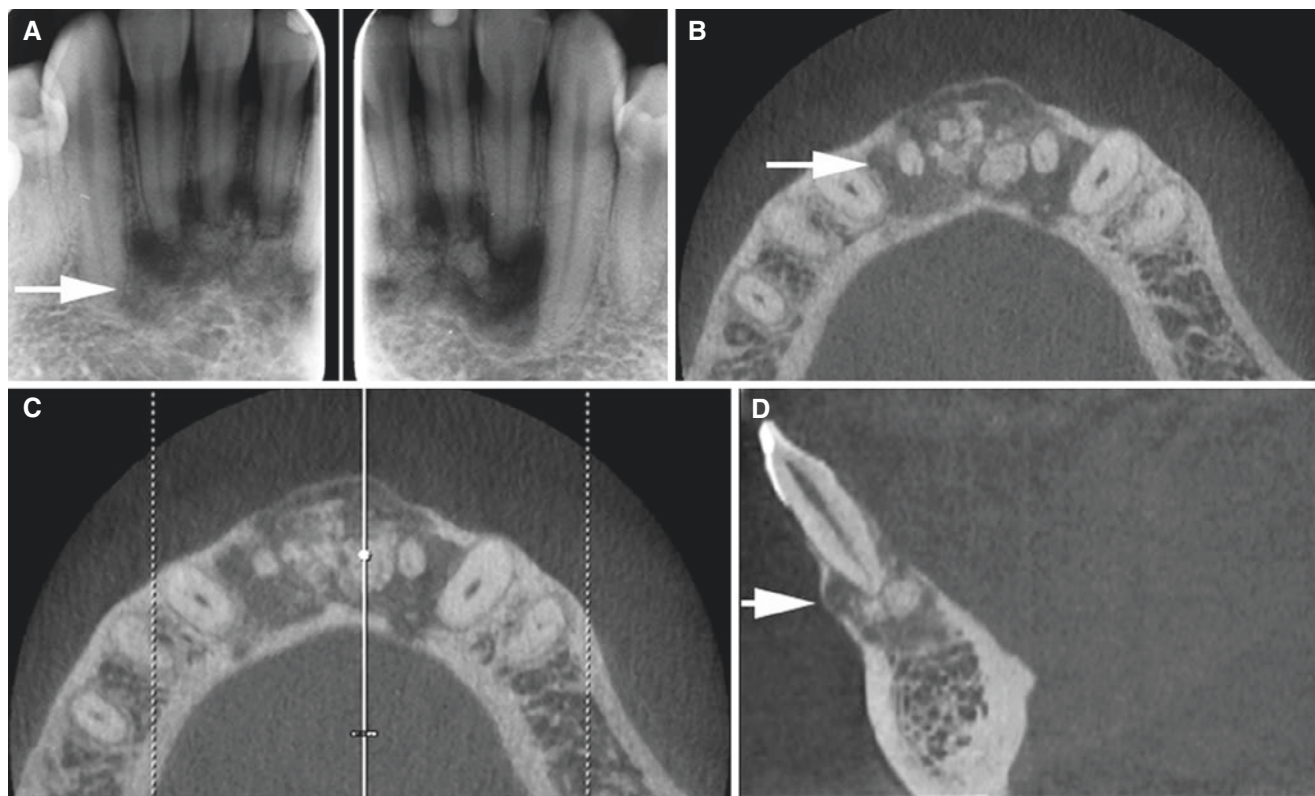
Fibro-osseous lesion (periapical osseous dysplasia or ossifying fibroma), mandible; 36-year-old female with painless swelling in the anterior mandible. Vital teeth. (A) Intraoral views show bone structure with mixture of radiolucencies and radiopacities (*arrow*). (B)
